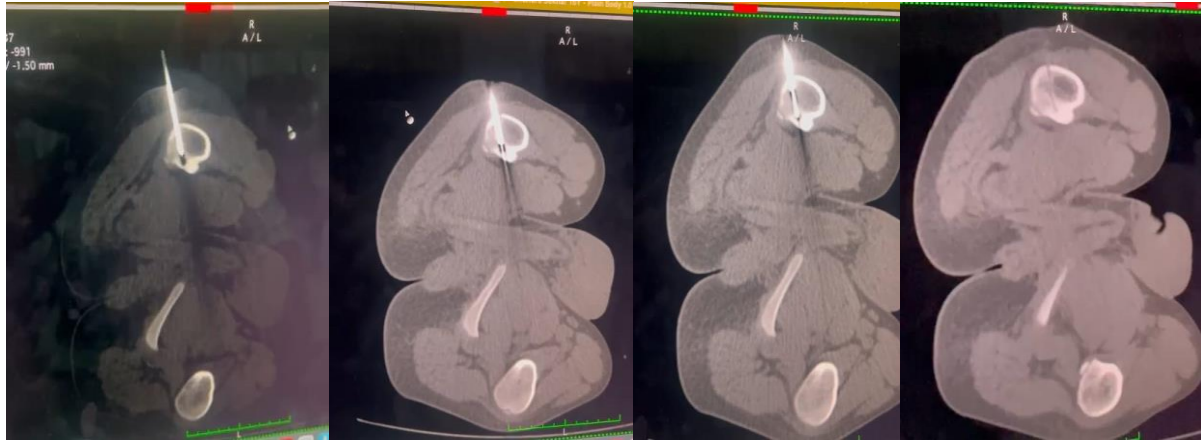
images showing serial axial sections of CT.
